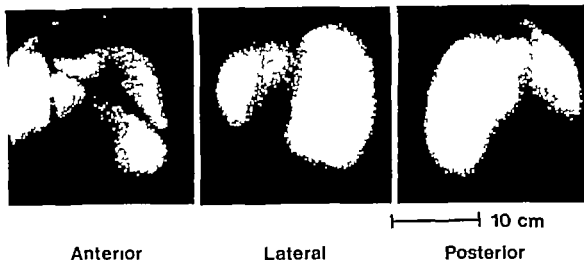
Spleen scans from ^{99m}Tc scintigraphy in the three routine projections of case of PV with moderate
